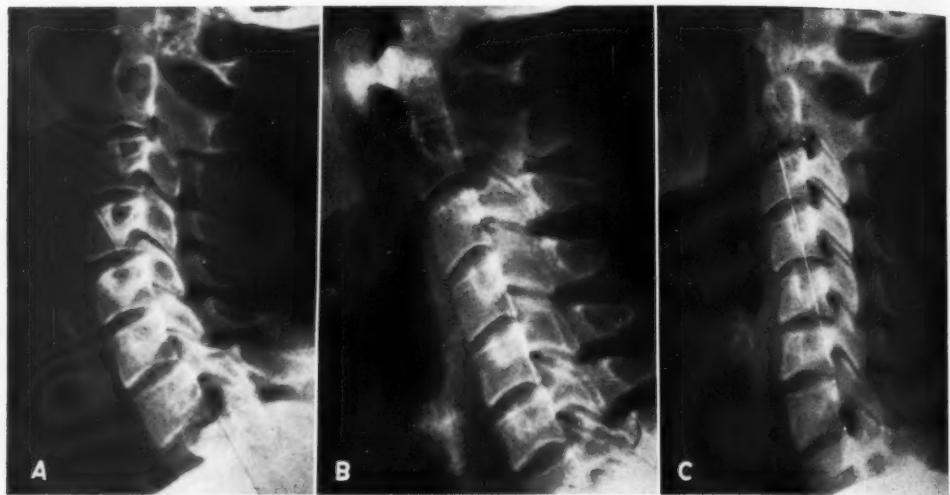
Lateral roentgenograms of the cervical spine made in the neutral position in three normal persons who denied a previous history of trauma to the neck.
